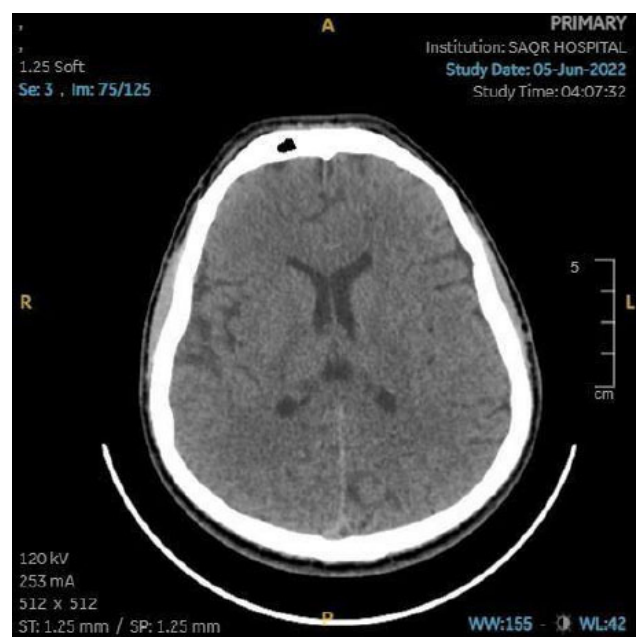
CT head or brain w/o contrast results of the patient, showing normal density of the gray and white matter with no definite focal or diffuse pathology. No intracranial bleed or hematoma. No intracranial space-occupying lesions.
